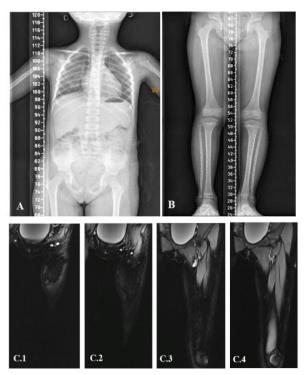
Patient's X-ray and MRI examination.
